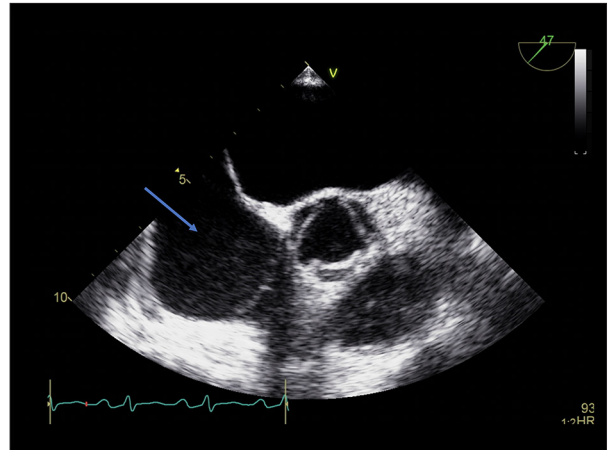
Transesophageal echogram (TEE) parasternal short view. There is resolution of the right atrial mass with fully intact tricuspid and aortic valves (arrow). The right atrial was noted to be slightly dilated. This was done after 6 weeks of rituximab, cyclophosphamide, epirubicin, vincristine, and prednisone (R-CHOP) alone.
